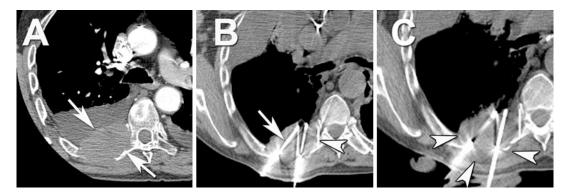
(a) Axial contrast-enhanced CT demonstrates a renal cell cancer metastasis involving the transverse process of T7, adjacent right rib, and chest wall (*arrows*), (b) two of 4 Perc-24 Endocare cryoprobes
